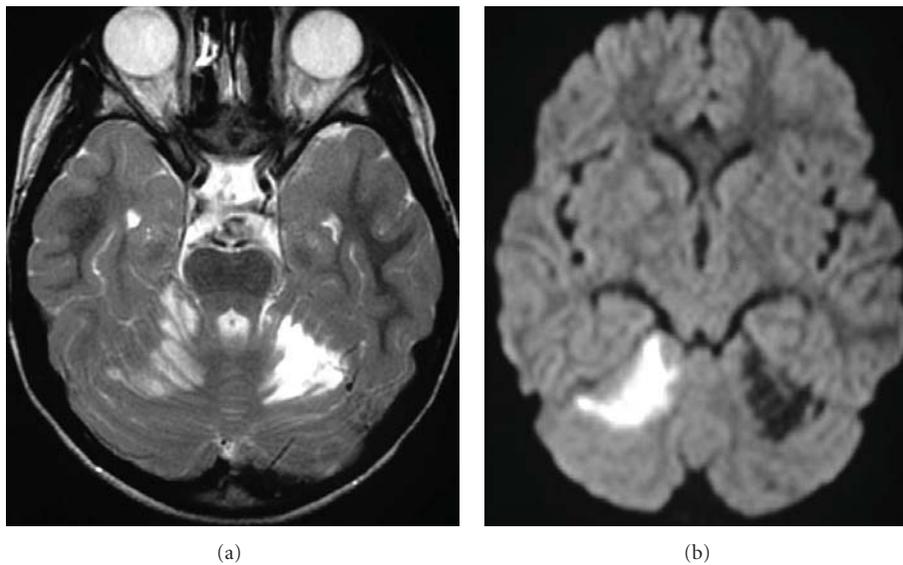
MRI axial T2-weighted (a) and diffusion-weighted (DWI) (b) images demonstrate the old infarction in the left superior cerebellar hemisphere and the new lesion in the right superior cerebellar hemisphere with identical distribution. The restricted diffusivity (high signal intensity in (b)) indicates a recent infarction.
